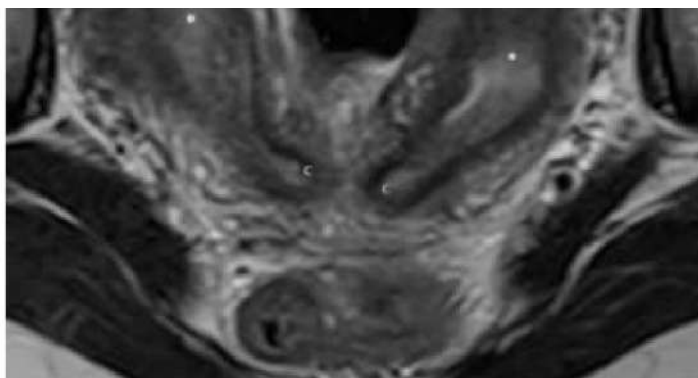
Axial T2-weighted pelvic MRI demonstrating uterine didelphys, with two separate uterine horns and endometrial cavities, consistent with the Mullerian anomaly associated with OHVIRA syndrome.
